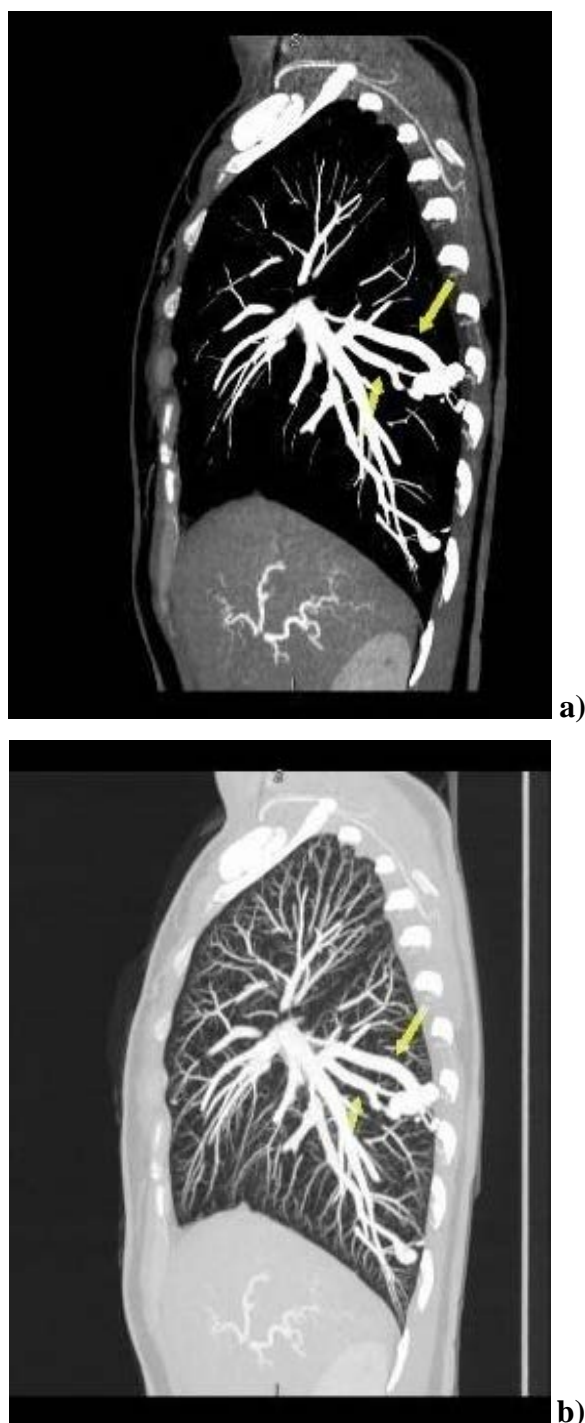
(a, b) – Multislice computed tomography pulmonary angiography (MSCT PA) findings: the largest pulmonary arteriovenous malformation (PAVM) with 7 mm diameter feeding artery and 9 mm diameter draining vein.
